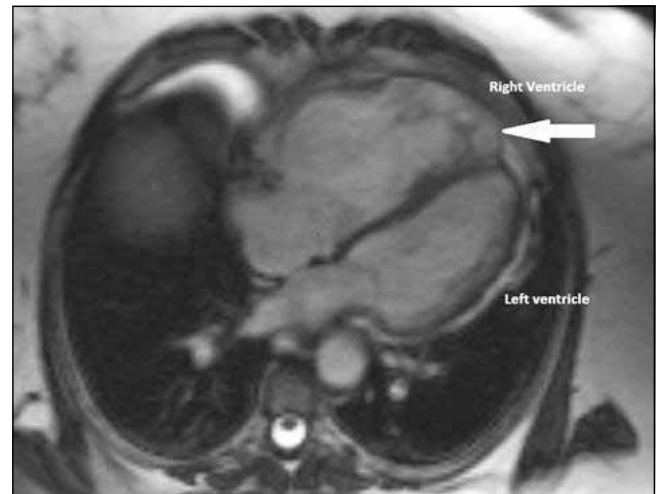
Cardiac magnetic resonance imaging showing a severely dilated right ventricle with multiple areas of wall thinning. There is aneurysm formation within the apical region (arrow). In contrast, the left ventricle is undilated.
